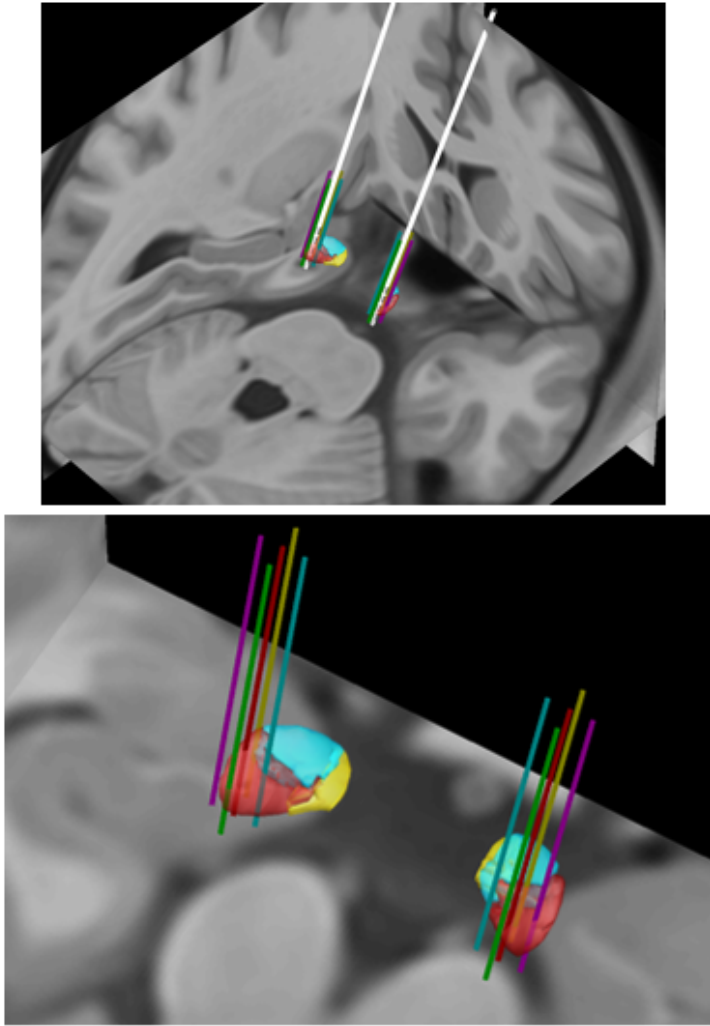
(a) DBS electrode reconstruction, b) microelectrode trajectory reconstruction. T2-weighted preoperative MRI was co-registered to postoperative T1-weighted MRI. The images were brought into DARTEL (Diffeomorphic Anatomical Registration Through Exponentiated Lie) space using a non-linear registration. The images were then brought into MNI space, electrode positioning was estimated, and the 3D reconstruction was performed using the STN subdivision atlas by [12].
